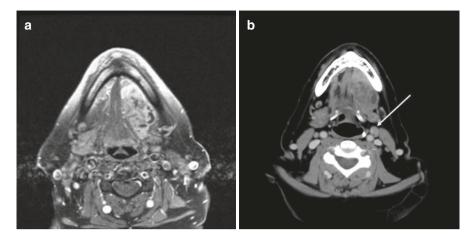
Adenoid cystic carcinoma of the sublingual gland imaged using both MRI (a) and CT scan with contrast (b). Arrow pointing to a metastatic level II lymph node
